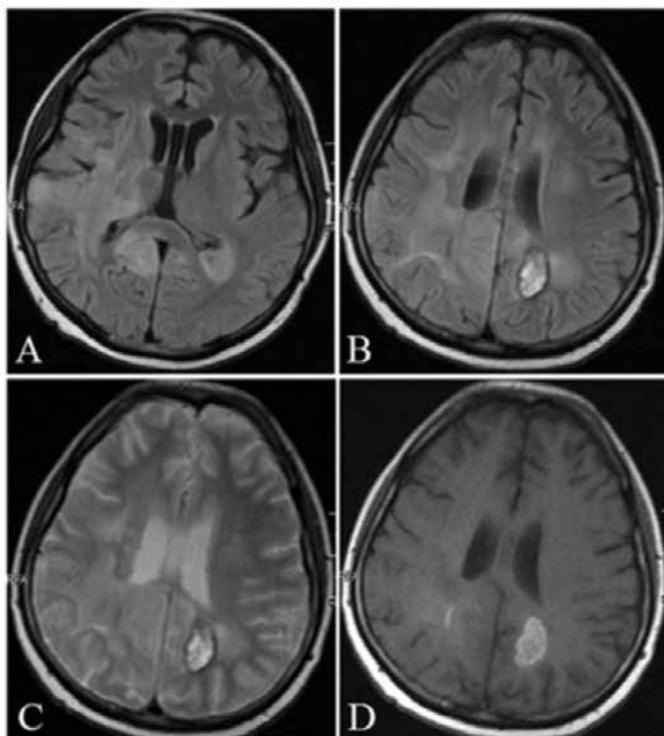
The mass effect of the lesion disappeared in the post-treatment. There is no right ventricle pressure or leftward shift. There is a mild improvement in the lesion areas seen as increased signal in the axial FLAIR (A, B) and T2-weighted (C) images. On the left parietal, signal increase possibly due to the bleeding caused by radiation necrosis can be seen in FLAIR, T2 and T1 images.
